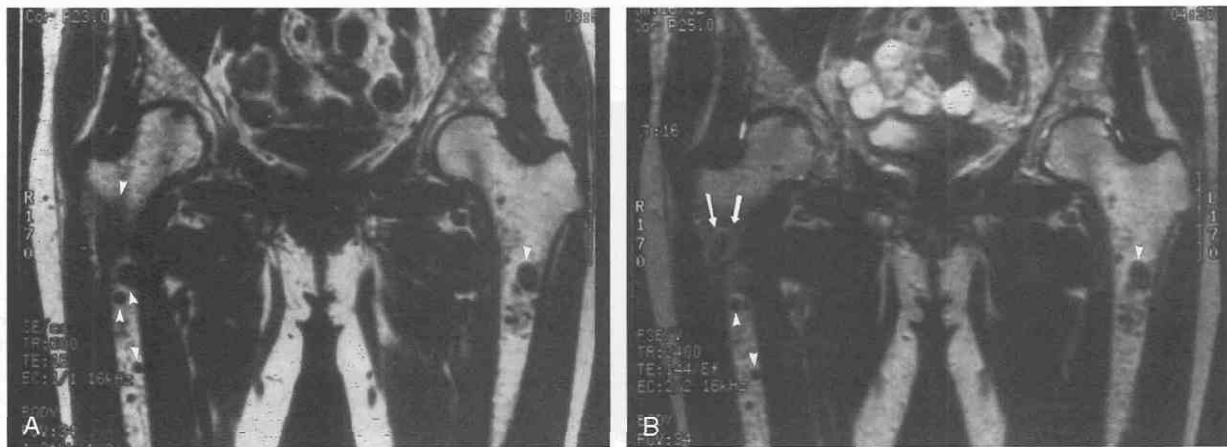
Multiple myeloma involvement of the proximal femoral heads in a 65-year-old woman. Coronal T1-weighted (A) and T2-weighted (B) MR images reveal multiple focal areas of marrow replacement (*arrowheads*) resulting from myelomatous involvement. In B, most of these lesions retain low signal intensity, although in the right femur the largest lesion shows mild increased intensity (*arrows*). The size of this lesion suggests impending pathologic fracture, and the right femur was prophylactically internally fixed with an intramedullary rod.
